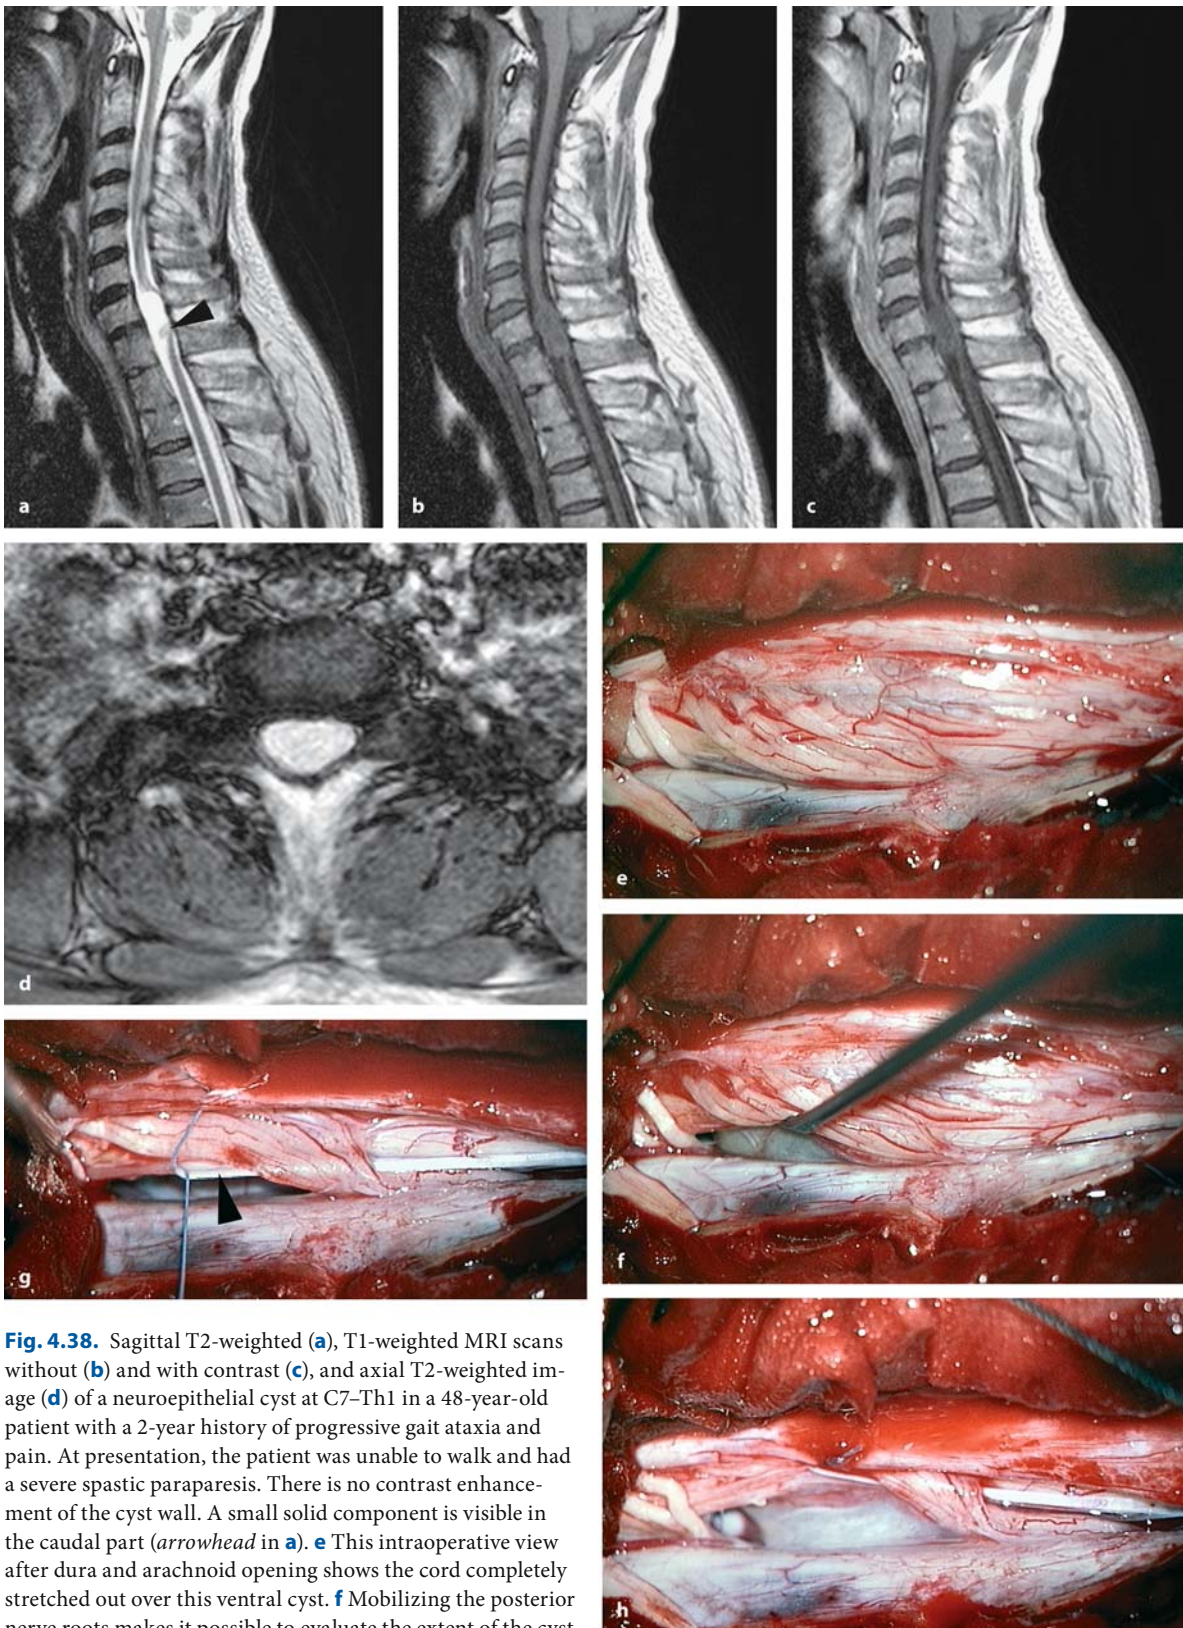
(Continued) The postoperative T1- (p) and T2-weighted images (q, r) demonstrate a normal-appearing spinal cord with no evidence of a tumor remnant. Postoperatively, the patient experienced complete pain relief with no neurological deficits
